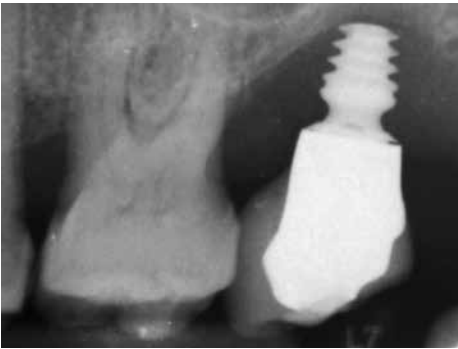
Patient 67 (maxilla), who presented at 3-year follow-up complaining of discomfort and crown mobility at #27. Clear periapical radiolucency surrounded the entire implant.
